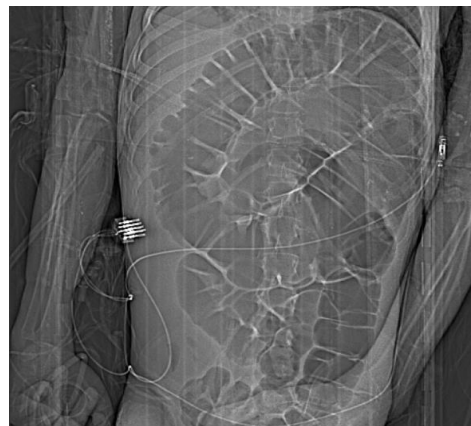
Upright abdominal radiograph demonstrating sigmoid volvulus
